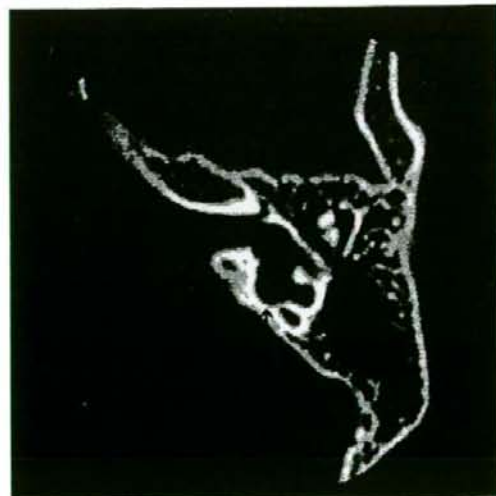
CT scan of Case 3. Left ear of a case of Mondini dysplasia. Note the presence of a common cavity, an enlarged basal turn of the cochlea and communication between the internal auditory meatus and cochlea. C = cochlea; V = vestibule; IAM = internal auditory meatus.
